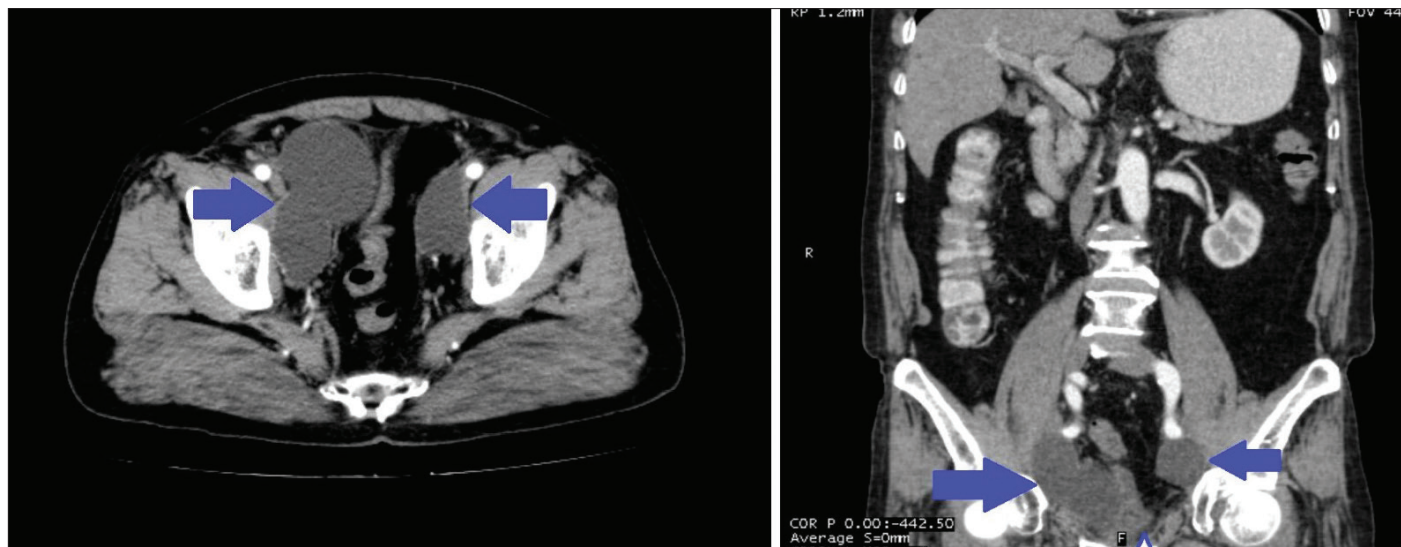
Demonstration of lymphocele formation in CT scan imaging vertically and coronally. In the right obturator region of the pelvic area, a cystic appearance with a lobulated contour approximately in size of 92×60mm, which is compatible with lymphocele, does not show contrast enhancement after intravenous contrast
